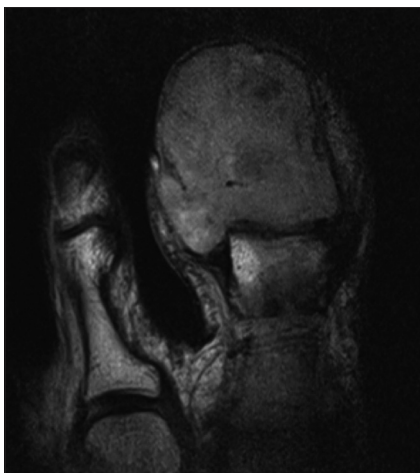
T1-Weighted MRI of great toe revealed expansile isointense lesion involving the distal phalanx of great toe with soft tissue extension
